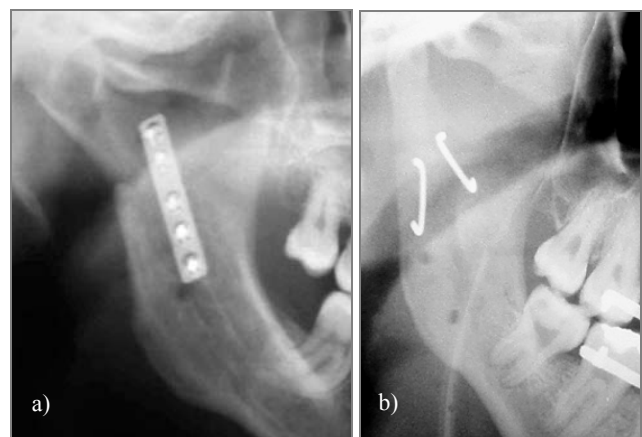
X-ray showing complications in fixations with a single compression plate – secondary dislocation of bone fragments (a) and proper adhesion with NiTi shape-memory staples used for fixation (b)
